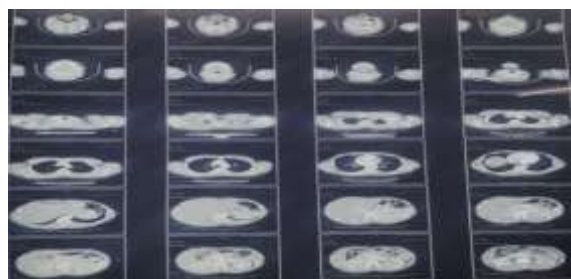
CT aortogram showing aortocaval mass.
